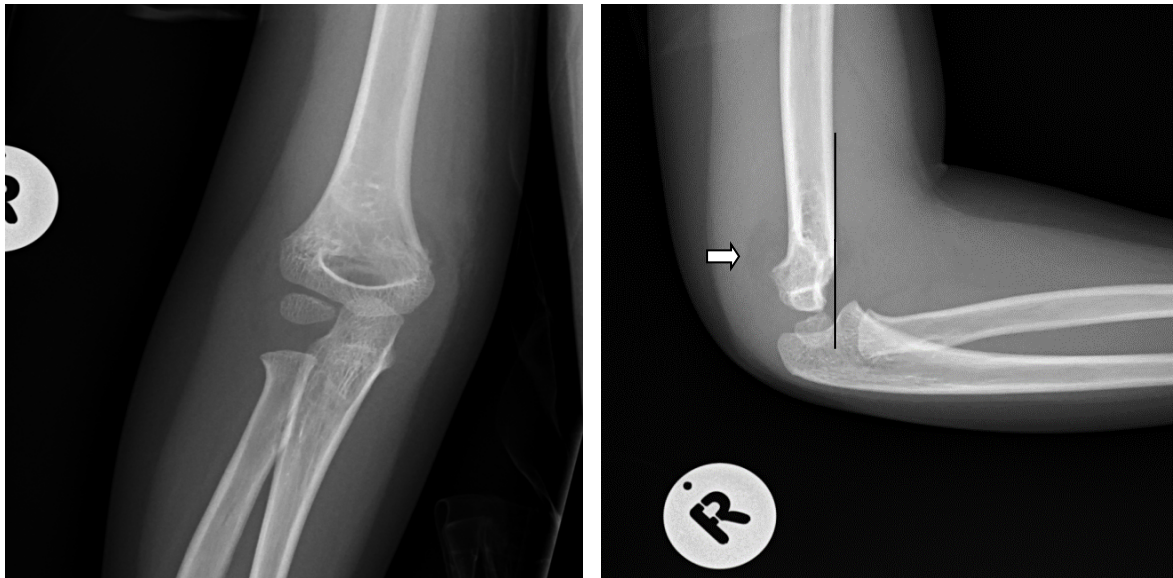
AP and lateral radiograph of elbow with a supracondylar fracture
